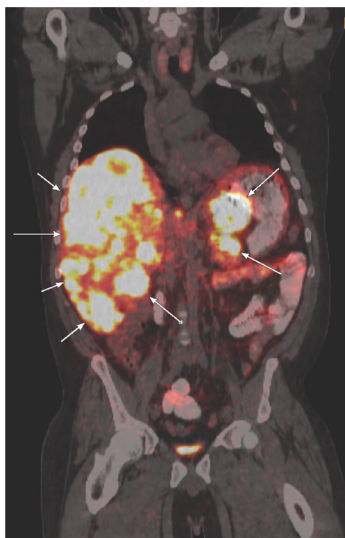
DOTATE PET scan. DOTATE avid hypodense hepatic lesions, for example segment 2, 7.0 cm × 6.5 cm (SUV 20.5) and segment 7, 5.6 cm × 4.8 cm (SUV 25.5); pancreatic tail lesion 5.4 cm × 4.0 cm (SUV 26.6); and upper abdominal nodal metastases. Arrows mark tumor. PET, positron emission tomography; SUV, standardized uptake value.
